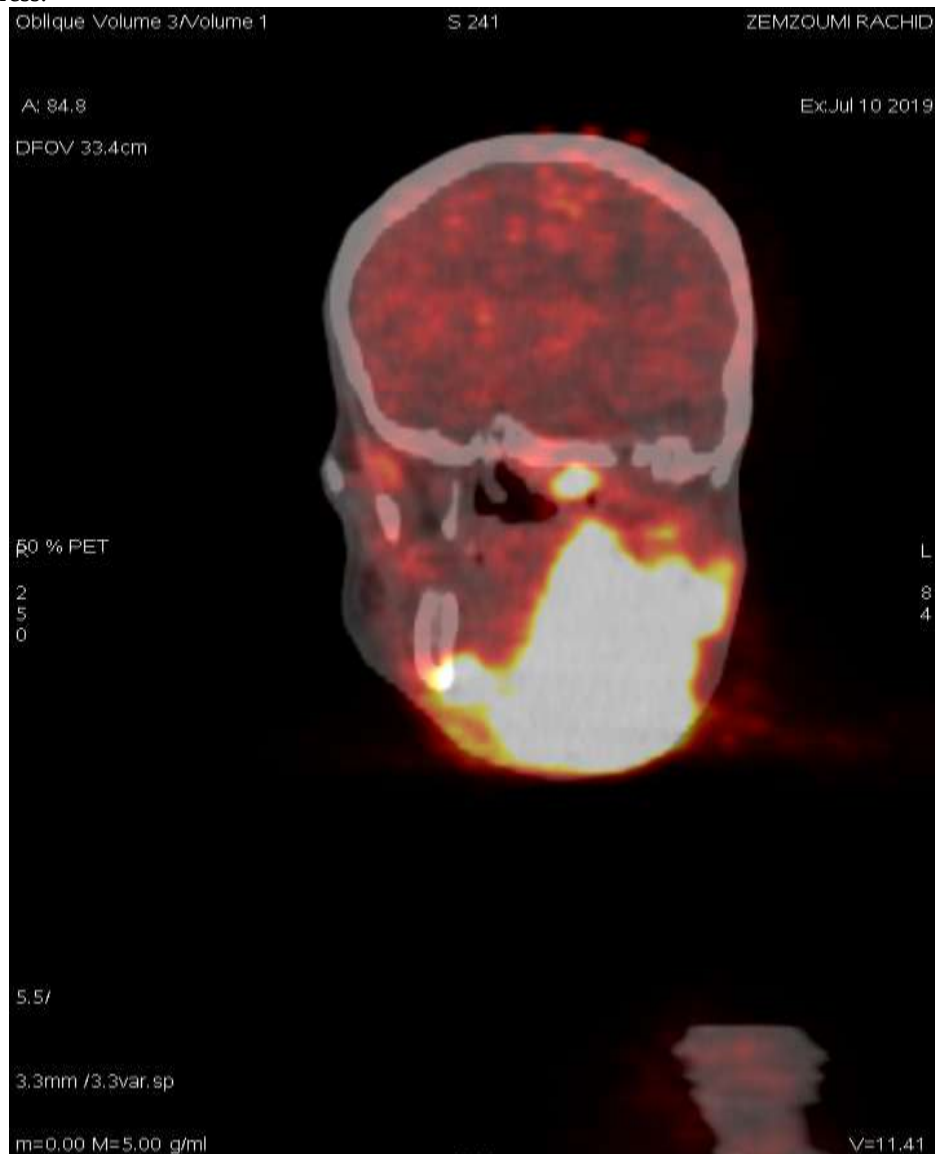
FDG-PET-CT images showing increased increased uptake of FDG in left mandibular bulky masse.
